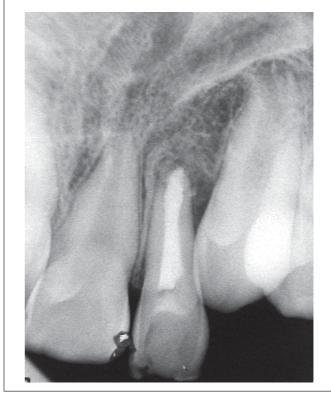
Periapical radiograph after 21 months of follow-up.
